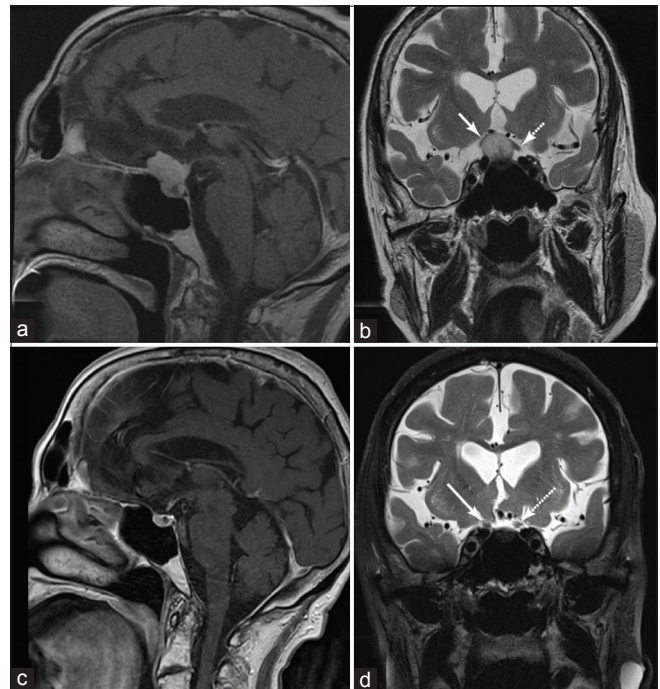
Sagittal postgadolinium-enhanced T1 magnetic resonance imaging (a) depicting a planum/tuberculum meningioma with coronal T2, (b) depicting elevation of the optic nerves bilaterally, right (solid arrow) greater than left (dashed arrow) causing peripheral vision loss. Postoperatively, her vision improved and 3 years after right eyebrow supraorbital craniotomy, sagittal T1 enhanced magnetic resonance imaging shows satisfactory gross total resection (c) with coronal T2 (d) showing resolution of the displaced optic nerves (solid arrow right, dashed arrow left).
